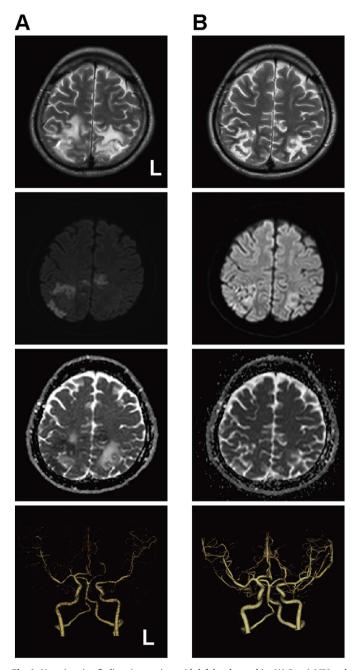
Neuroimaging findings in a patient with left-hand agraphia. (A) Day 1 MRI and 3D-computed tomography angiography (CTA) findings. The right, right middle, left middle, and left figures are T2-weighted and diffusion weighted images, apparent diffusion coefficient maps, and 3D-CTA, respectively. (B) Follow-up MRI (day 27) and 3D-CTA (day 16). Abnormalities in the initial neuroimaging study were improved, suggesting reversible cerebral vasoconstriction syndrome with posterior reversible encephalopathy syndrome.
